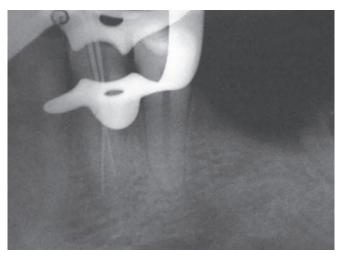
Master cone radiograph (Case 2)
